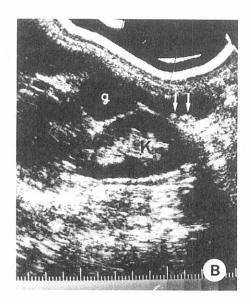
(MF). A. Oral cholecystogram shows an aggregate of approximately 20 calcific densities, apparently outside the gallbladder. B. Sagittal ultrasonography shows a bicameral gallbladder (g) and calculi in its fundal chamber (arrows). K=right kidney.
